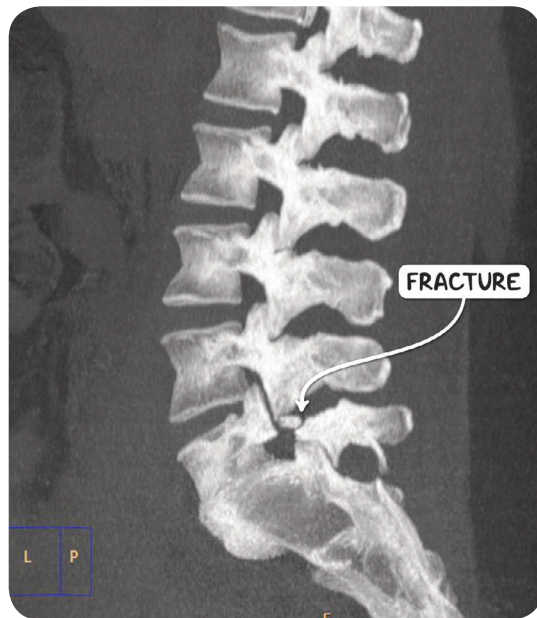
A CT scan of the spine in the sagittal plane demonstrating spondylolisthesis of the L5/S1 intervertebral joint.
